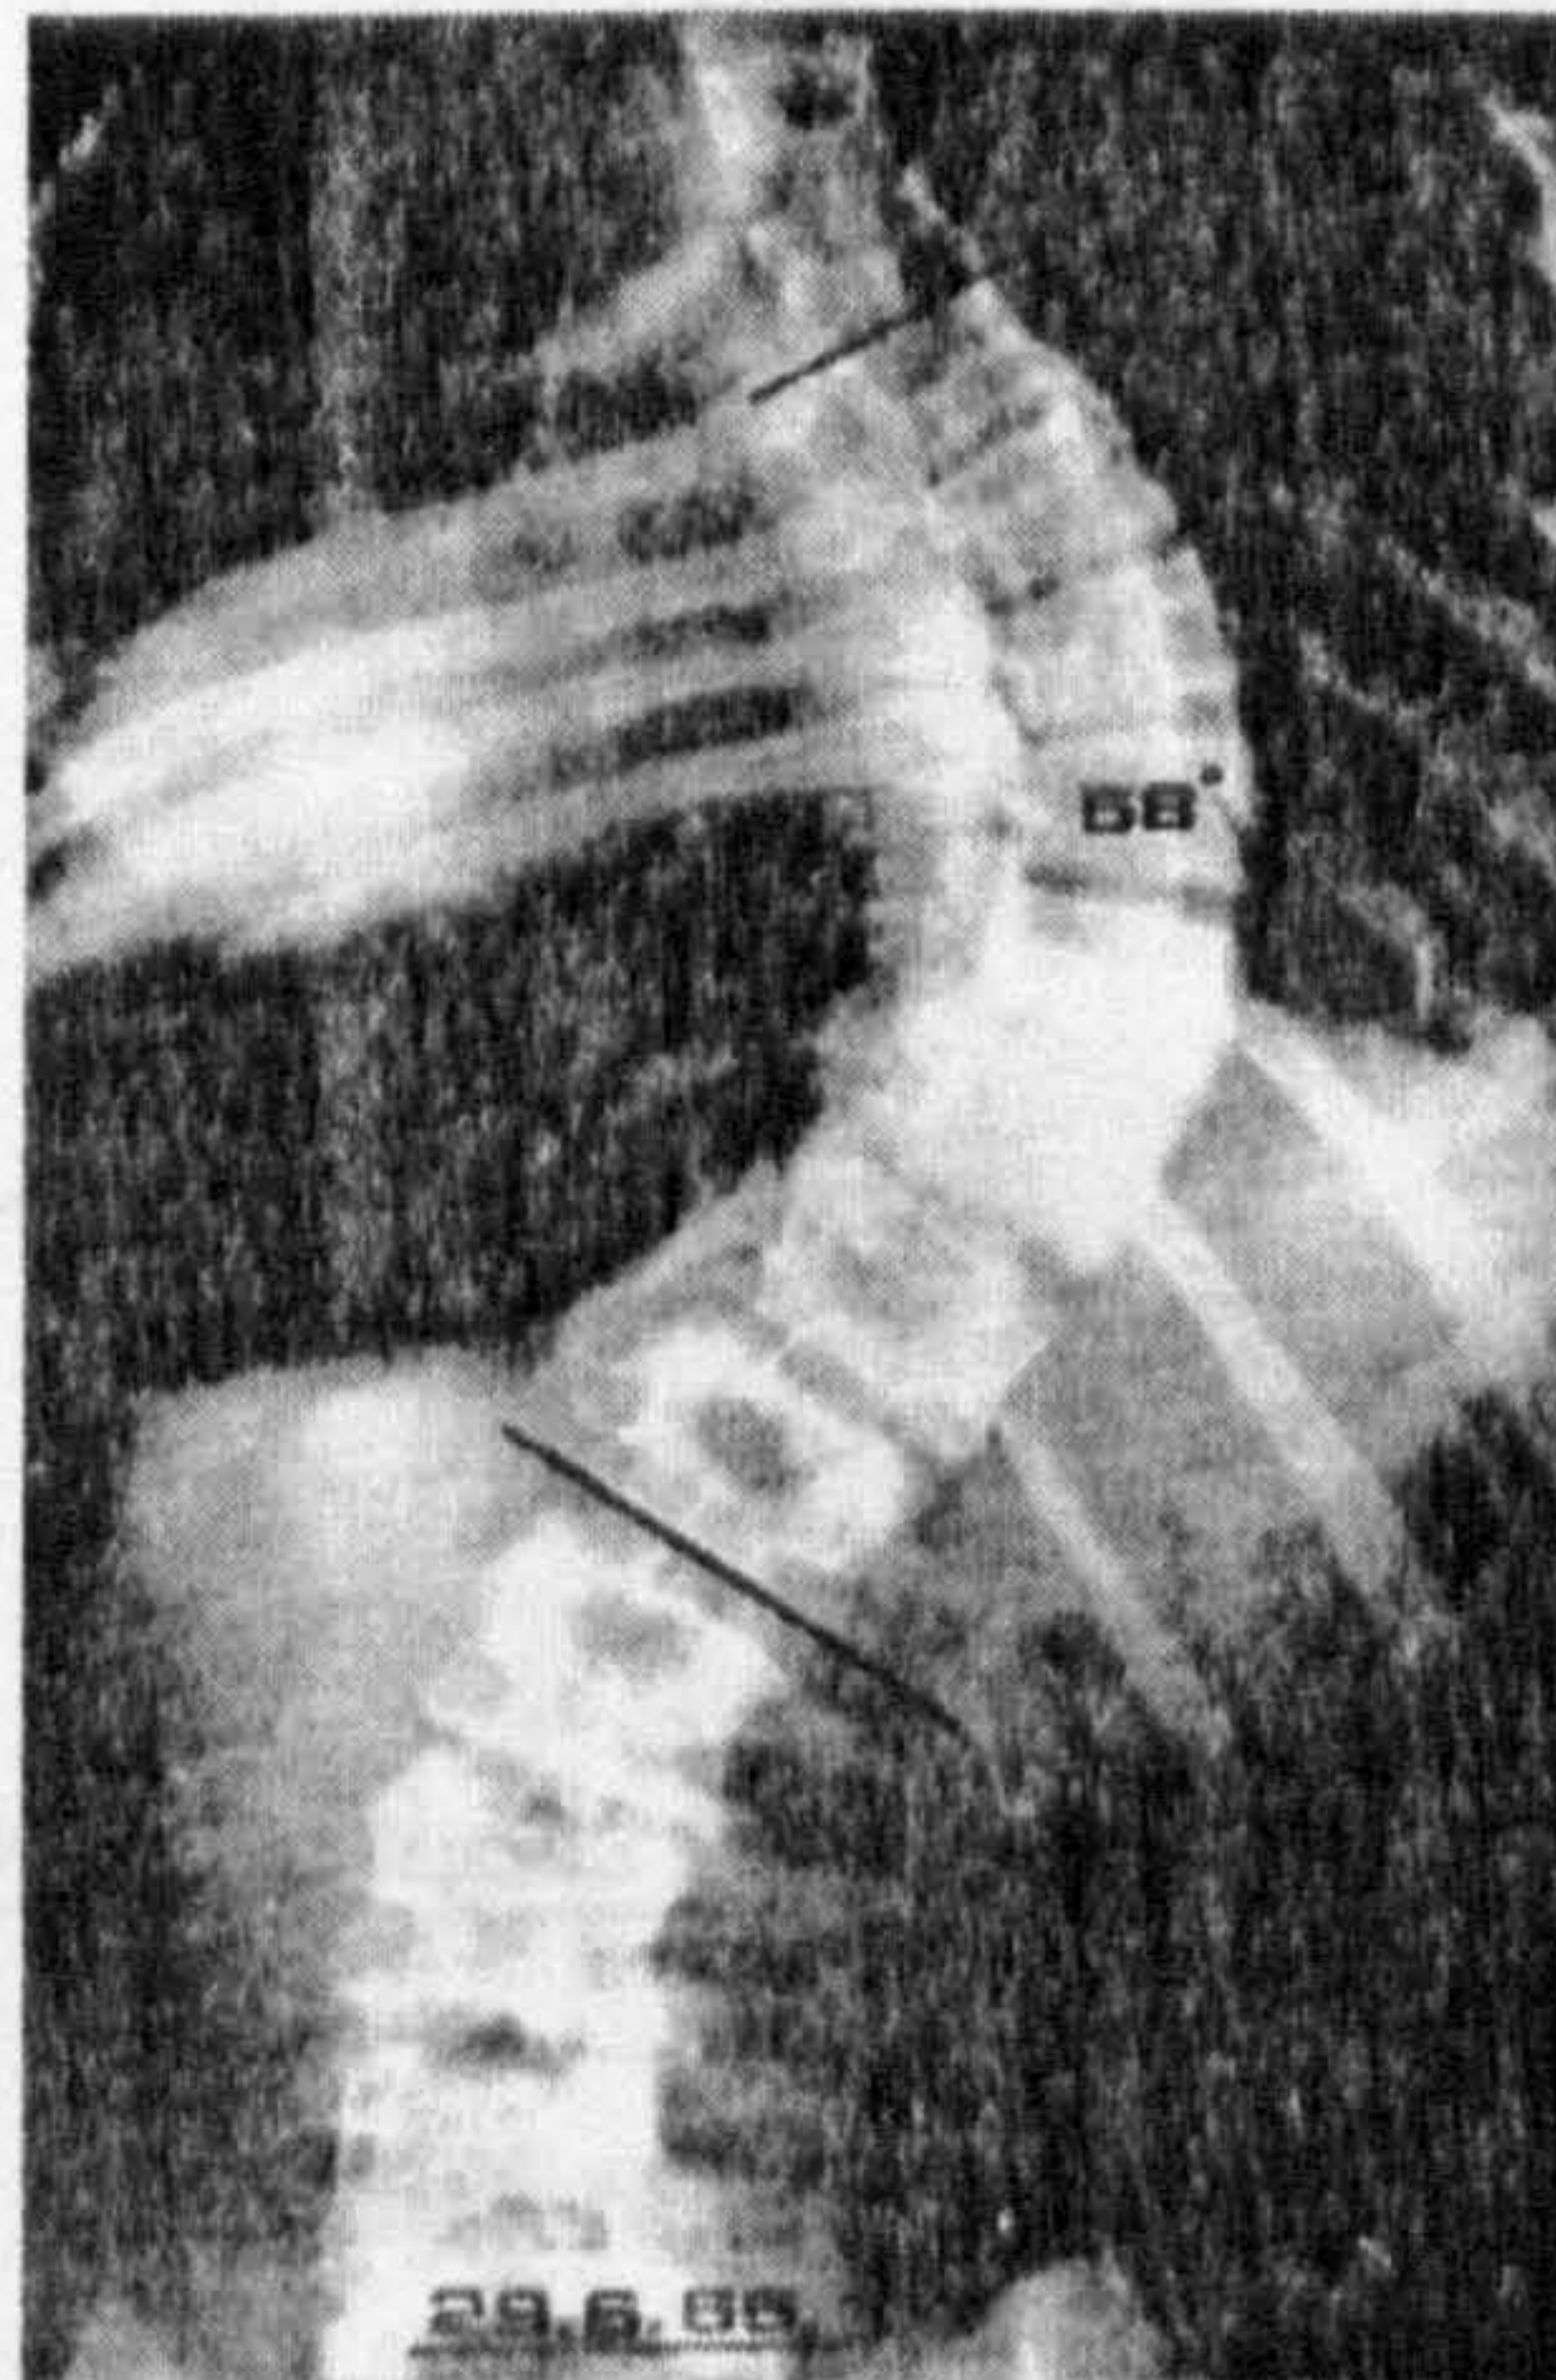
Radiograph of a thoracic structural curve (from James 1976).
